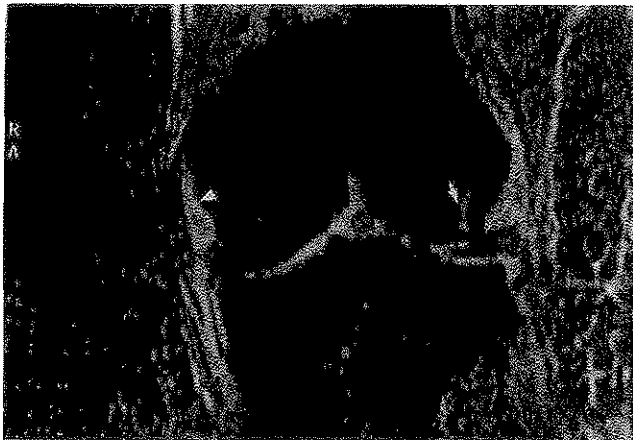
MRI scan of the knee: T_2^* -weighted coronal image. Observe the interruption of the thin, low signal intensity medial collateral ligament (black arrow). The ligament is displaced from its attachment on the medial tibial condyle by a collection of high-signal-intensity hemorrhage and edema (white arrowhead). Also note the hyperintense signal within the subchondral bone of the lateral femoral condyle, consistent with a bone contusion (white arrow) (Courtesy of Kenneth B. Reynard, M.D., Center for MRI, Ltd., Denver, Colorado).
